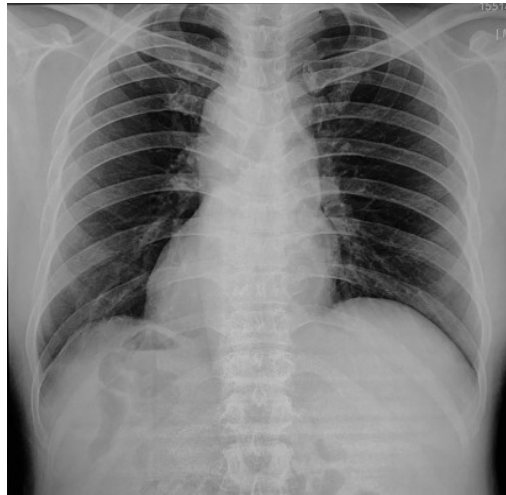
Chest radiography shows right-sided positioning of cardiac
